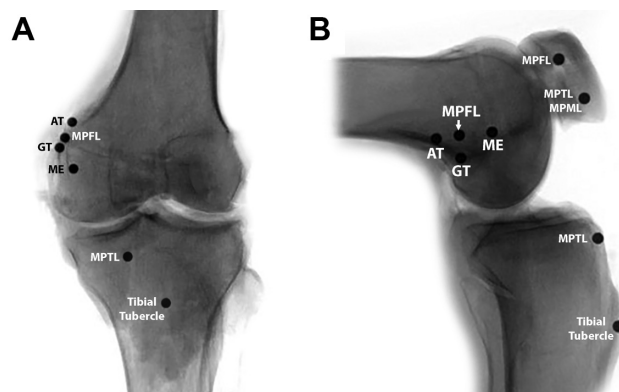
(A) Anteroposterior and (B) lateral radiographic views of a left knee demonstrating the positioning of the spherical markers and their relationship to surgically relevant landmarks. AT, adductor tubercle; GT, gastrocnemius tubercle; ME, medial epicondyle; MPFL, medial patellofemoral ligament; MPML, medial patellomeniscal ligament; MPTL, medial patellotibial ligament.
